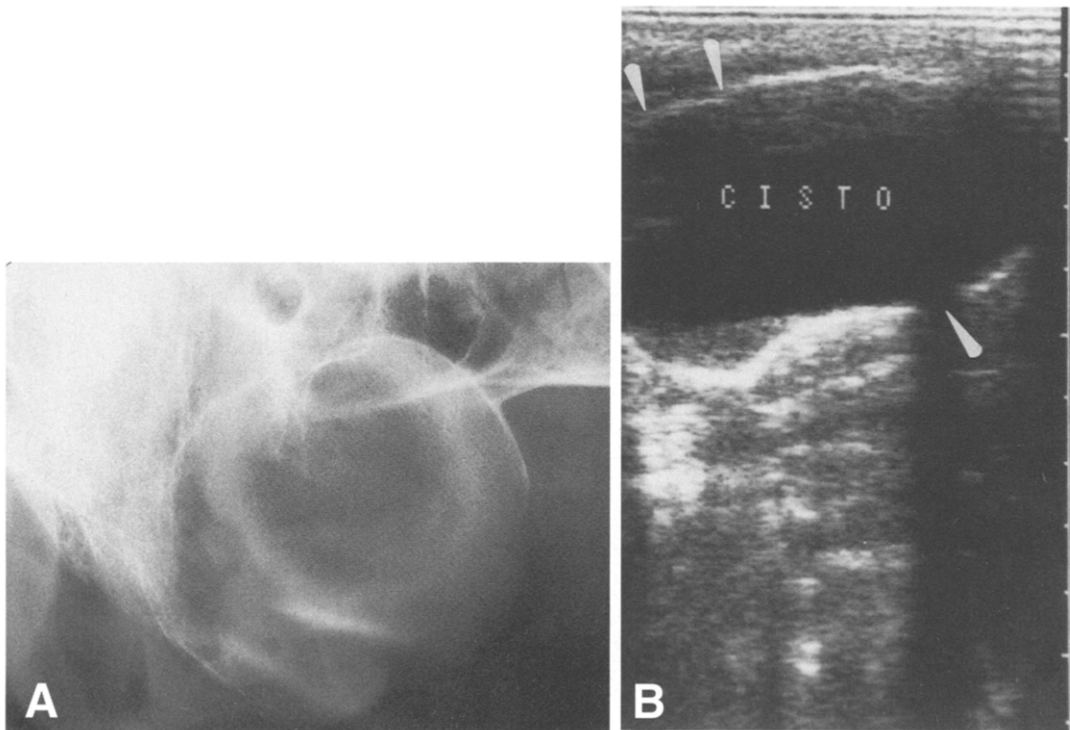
A, Occlusal radiograph of radicular cyst of anterior area of maxilla in edentulous 65-year-old white man. Lesion shows well-defined unilocular radiolucent image circumscribed by sclerotic radiopaque line. B, US image of same lesion shows anechoic aspect of cyst with liquid content. Interruption of buccal (*two arrows*) and palatal (*one arrow*) cortical surface of the maxilla is also demonstrated.
